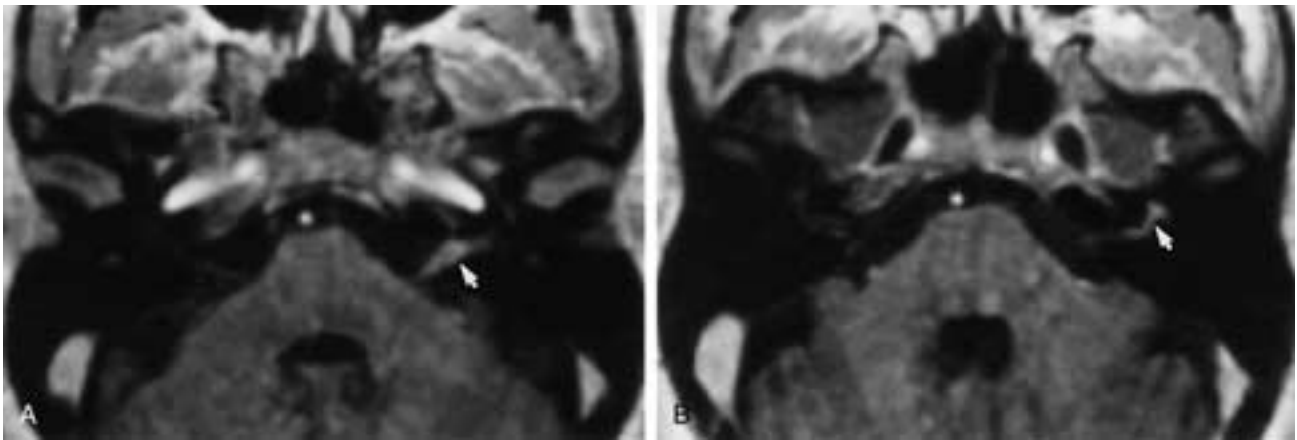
Primary left facioacoustic nerve lymphoma. A, Gadolinium T1-weighted image shows a moderately enhancing fusiform tumor (*arrow*) along the left facioacoustic nerves in the IAC extending into the CPA. The pointed medial extension is atypical of schwannomas. B, Gadolinium T1-weighted image shows marked enhancement (*arrow*) along the labyrinthine facial nerve and in the geniculate region. The patient had hearing loss and facial palsy.
